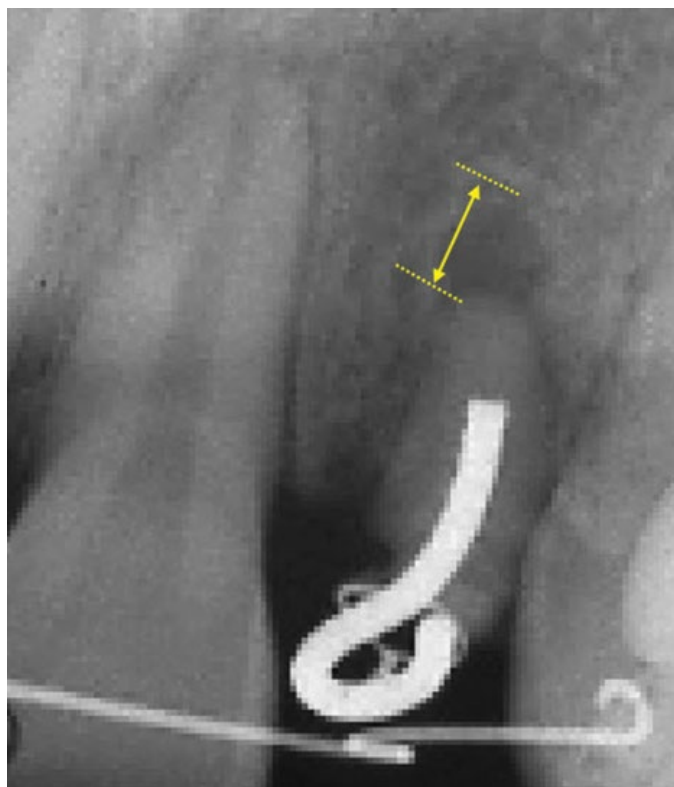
Periapical radiograph revealing extrusive movement of maxillary lateral root.
